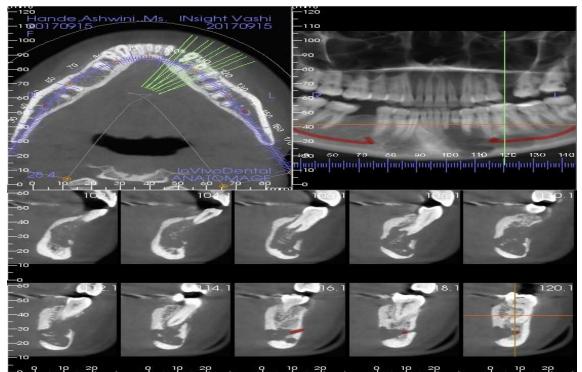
Pre-operative CBCT sections showing involvement of mandibular bone with perforation of both lingual and buccal cortices
